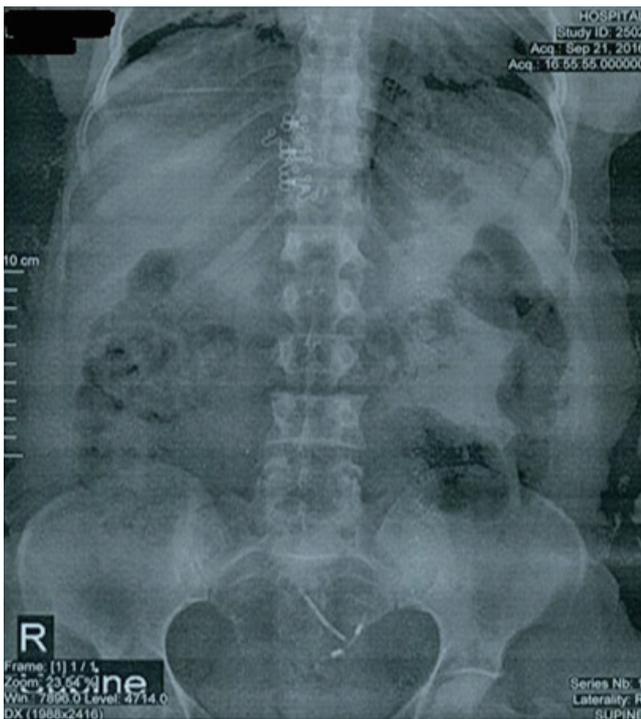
Migrated intrauterine device and stone seen on abdominal plain X-ray. In abdominal plain X-ray, intrauterine device (IUD) looks upside down (in reverse position) in uterine cavity, it's also left leaning instead of longitudinal position along the middle line of the uterus. A few stones has been formed on the right branch of the IUD which shows passage of the time.
